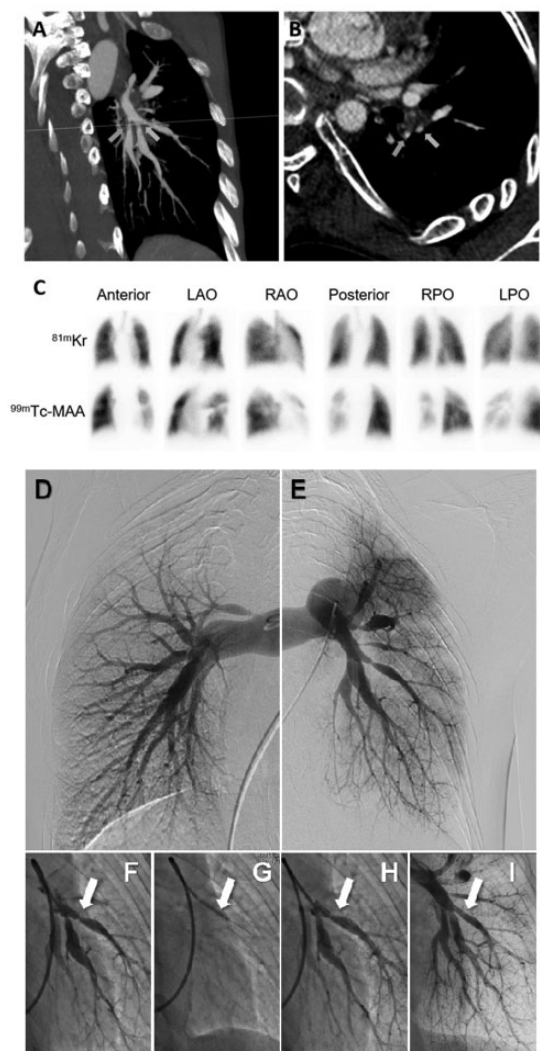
(a) Oblique coronal, (b) oblique axial Image of maximal intensity projection computed tomography angiography (CTA) focusing on the strictures (arrows) in the left pulmonary artery branches. (c) Images of ^{81m}Kr ventilation scintigraphy are shown in upper row. Images of ^{99m}Tc-macro aggregated albumin (MAA) lung perfusion scintigraphy is shown in the lower row. There is significant decrease of ^{99m}Tc-MAA uptake. LAO: left anterior oblique. RAO: right anterior oblique. RPO: right posterior oblique. LPO: left posterior oblique. (d)–(i) Pulmonary artery angiographs (PAGs) of the patient. (d) PAG of right and (e) left pulmonary arteries before balloon pulmonary angioplasty (BPA). (f) Selective PAG of the left lower branches and target lesion of BPA (arrow). (g) Balloon (arrow) dilating the lesion. (h) Improved blood flow distal to the lesion (arrow) right after BPA. (i) PAG at 18 months follow-up showing improved dilation (arrow).
